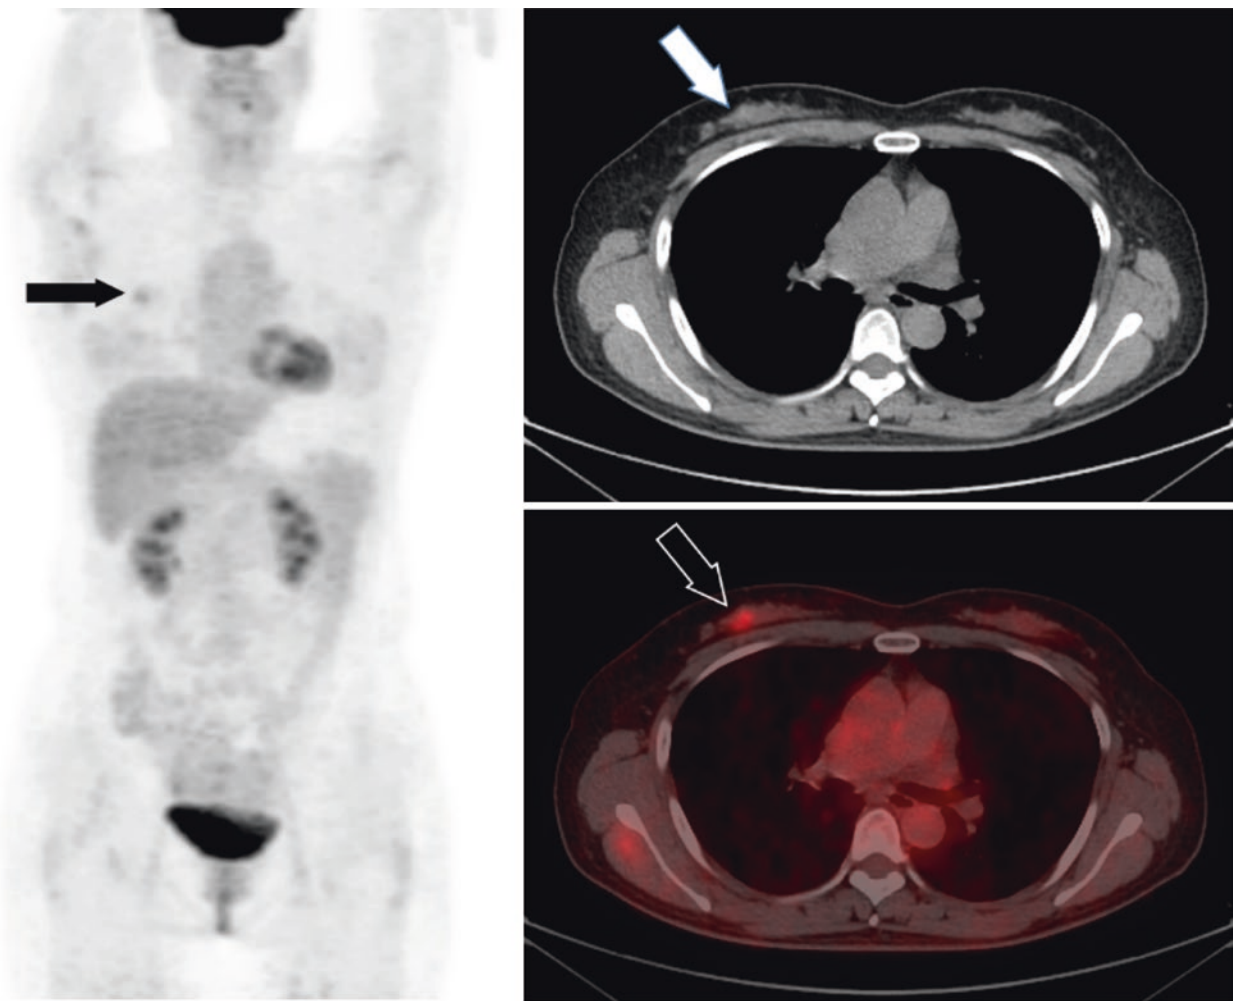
A 56-year-old woman with suspicious left lung adenocarcinoma (no increased activity) undergoing ^{18}F -FDG PET/CT for tumor staging. An incidental ^{18}F -FDG focus (black solid arrow) was seen in the upper and medial quadrant of the right breast on coronal maximum
